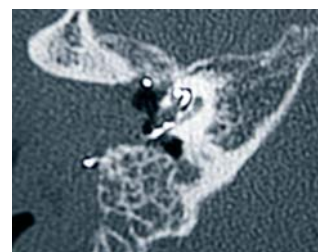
Patient 2; axial CT scan of the right side, fat obliterated mastoid and 6 electrodes placed in the second cochlea turn.
